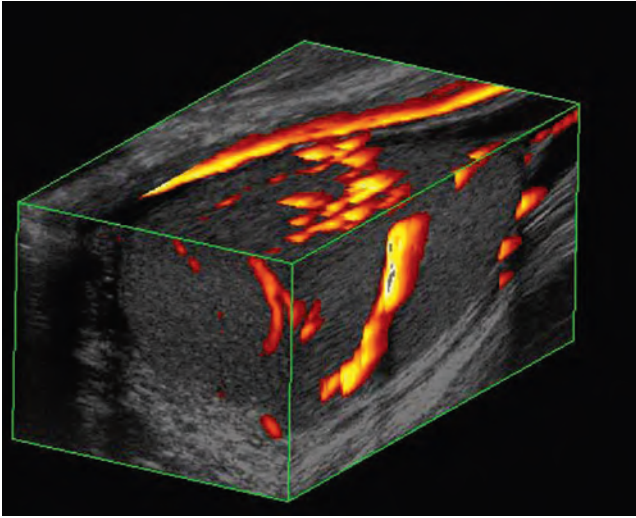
Three-dimensional image of the testis demonstrating intratesticular blood flow on power Doppler. The image can be virtually rotated and manipulated to produce unique anatomic perspectives. (Used with permission by BK Medical, Peabody, MA.)
